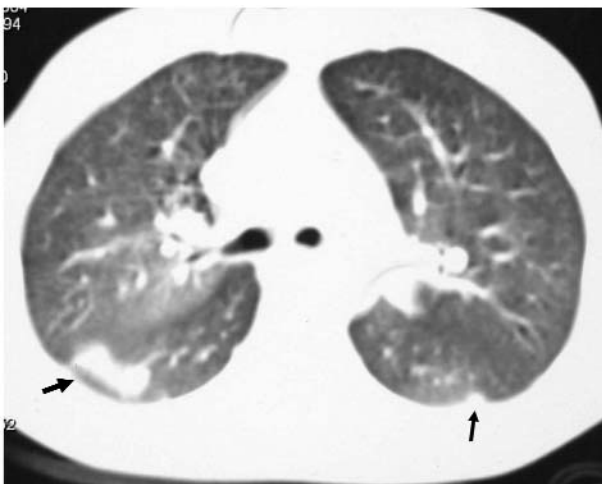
Computed tomographic scan of the chest shows bilateral peripheral nodules and a ground-glass appearance in the lung parenchyma.
